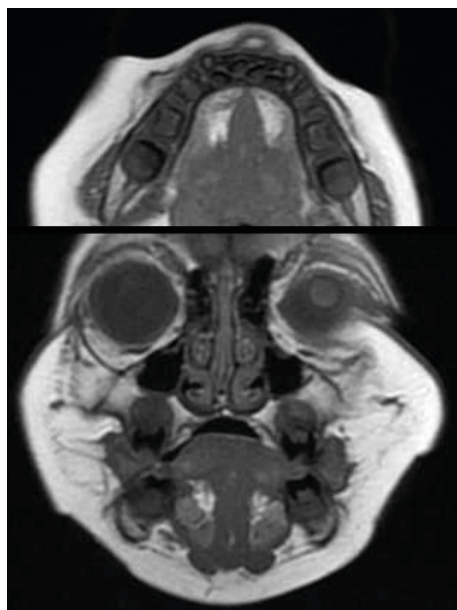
Axial and coronal MRI of the face and neck showing normality
